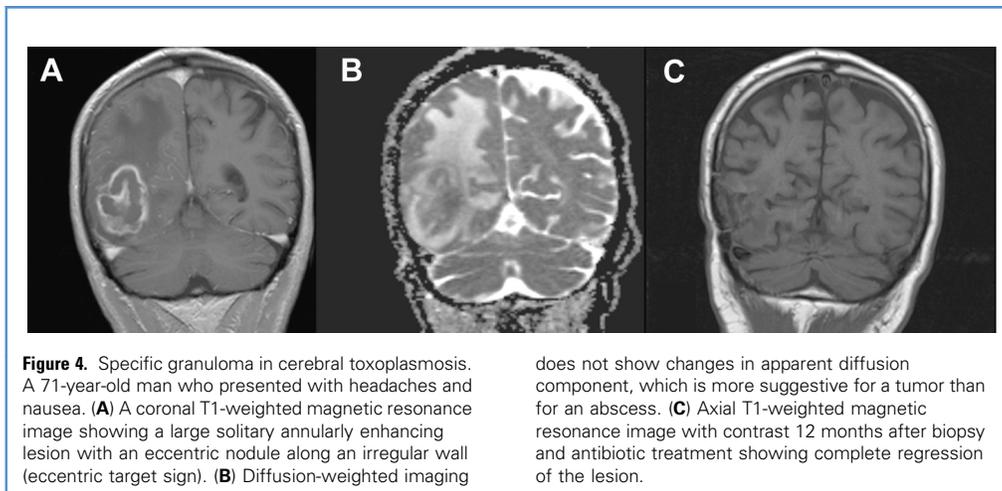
Specific granuloma in cerebral toxoplasmosis. A 71-year-old man who presented with headaches and nausea. (A) A coronal T1-weighted magnetic resonance image showing a large solitary annularly enhancing lesion with an eccentric nodule along an irregular wall (eccentric target sign). (B) Diffusion-weighted imaging
